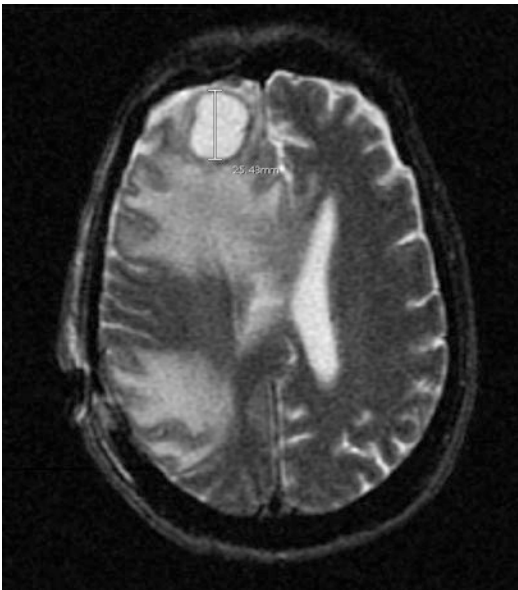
T2-weighted MRI image showing a hyperintense brain abscess in the frontal region
